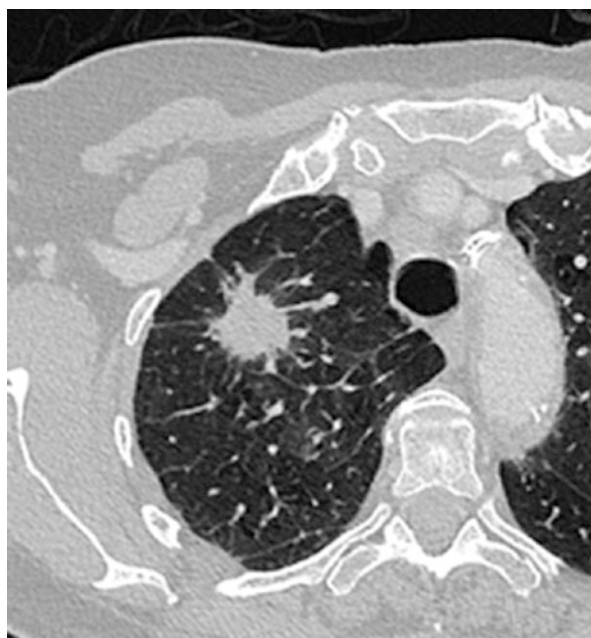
Right upper lobe lung carcinoma with spiculated margins extending to the visceral pleural surface seen on axial thin-section contrast-enhanced CT
